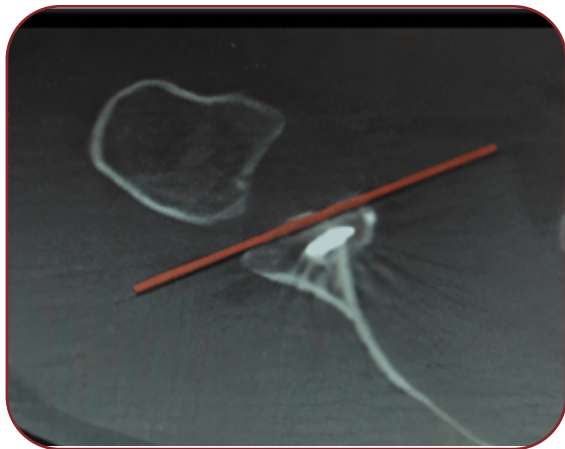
Graft position in axial plane. In axial computed tomography (CT) plane, measurement of the distance between graft and glenoid surface. Distance is characterized as adequate when it is 2-5 mm.
